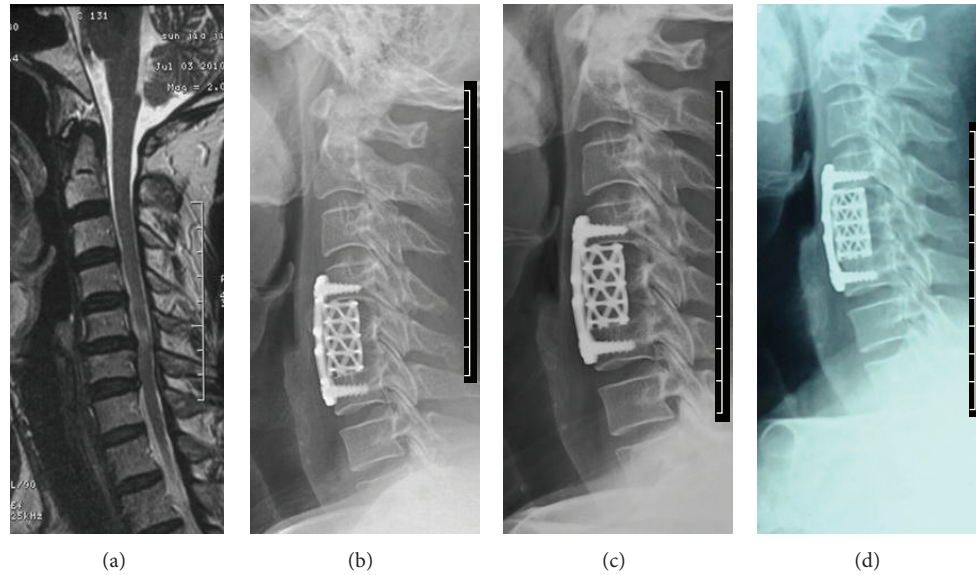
A 60-year-old man underwent anterior cervical corpectomy and fusion with a titanium mesh cage for CSM. (a) The compression located in the C5 level on the cervical MRI. (b) Lateral radiograph immediately after surgery. (c) 3 months after surgery the endplates were clear. (d) Two years after surgery the endplates were undefined and mild subsidence was observed.
